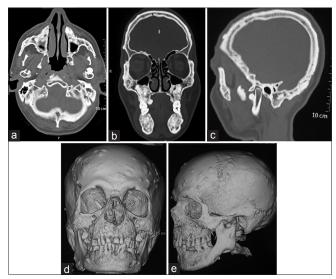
(a) Axial section shows near total obliteration of the right and partial obliteration of left maxillary sinus. Diffuse radiopaque areas are seen in the maxilla and zygomatic bones. Bilateral pterygoid plates show expansion. (b) Coronal section shows obliteration of the right and left maxillary sinuses. Diffuse radiopaque areas are seen which have caused expansion of maxilla and zygomatic bone. Dense bony exostoses are seen projecting from the palatal surface. Marked mediolateral expansion seen of the mandible is seen. (c) Sagittal sections of computed tomography scan show dense radio-opacities in the frontal and occipital bones. A well-defined dense round bony exostosis is seen attached to the left condyle. (d and e) Three-dimensional reconstruction on computed tomography scan showing multiple osteomas of frontal and parietal bones along with diffuse bony swelling of the maxilla and mandible. A well-demarcated osteoma of left sigmoid notch and a surgical defect on the left lower border of mandible is appreciated
